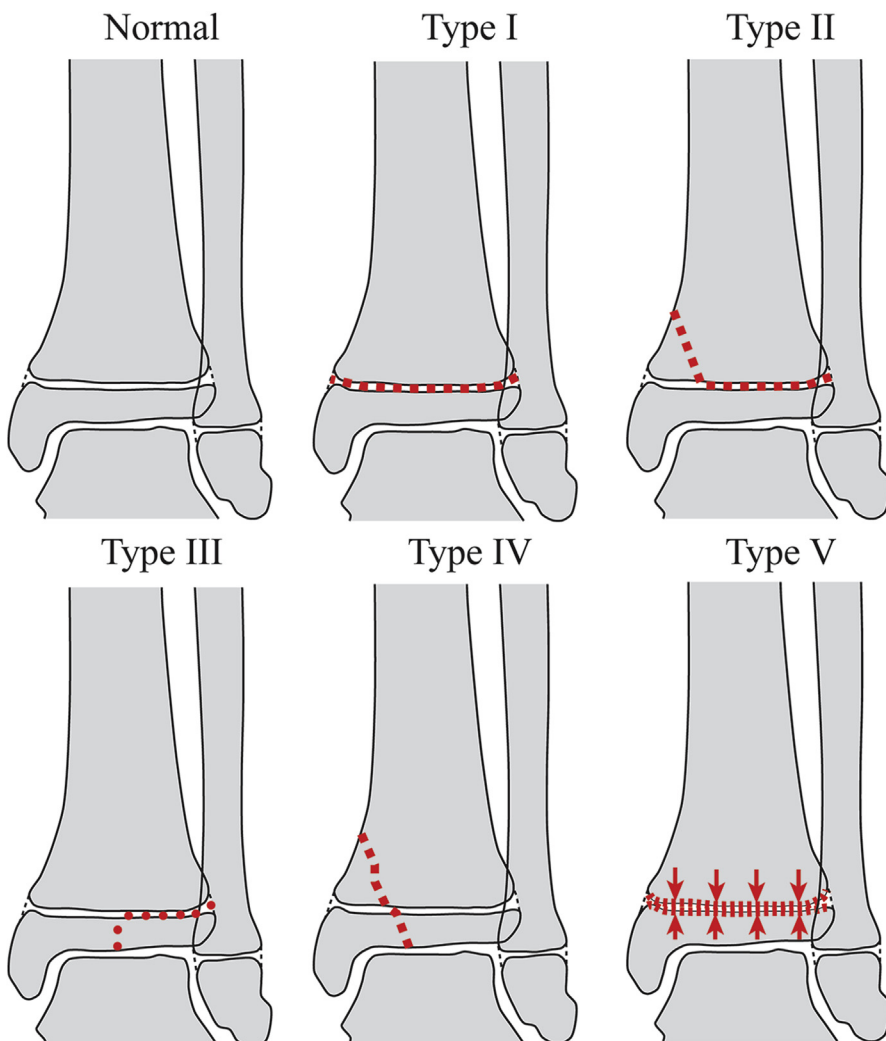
Salter-Harris Classification in the distal tibia. Type I fracture demonstrates physeal distance from the metaphysis without radiographic evidence of fracture through the ossified bone. Type II fracture is the most common fracture pattern, with the fracture line extending from the physis into the metaphysis. Type III fracture is intra-articular and extends from the epiphyses into the physis. Type IV fracture is also intra-articular and involves both epiphyseal and metaphyseal components with the fracture line passing across the physis. Type V fracture is considered a crush injury of the physis and is very uncommon.
